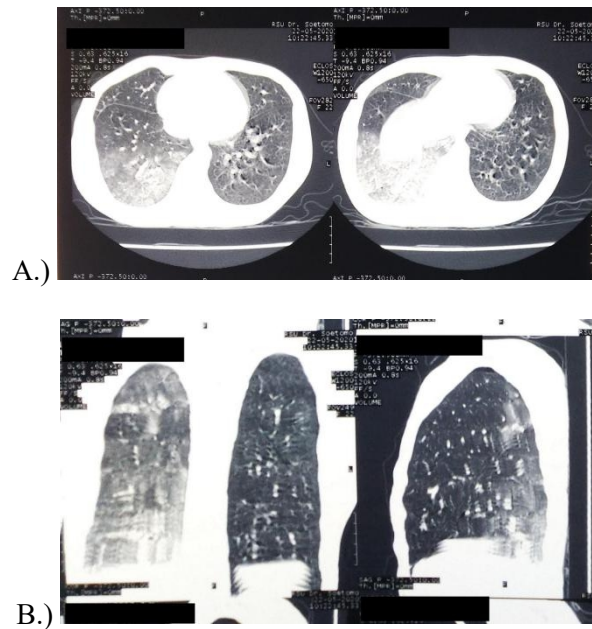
Patient thoracic HRCT obtained a picture of pneumothorax that has been mounted chest tube with ground-glass opacity (GGO) in the right lung can be a differential diagnosis of reexpansion pulmonary or pneumonia. A.) Axial pieces appear GGO posteriorly, B.) Image of a sagittal section showing GGO in the superior and inferior lobes of the right lung
